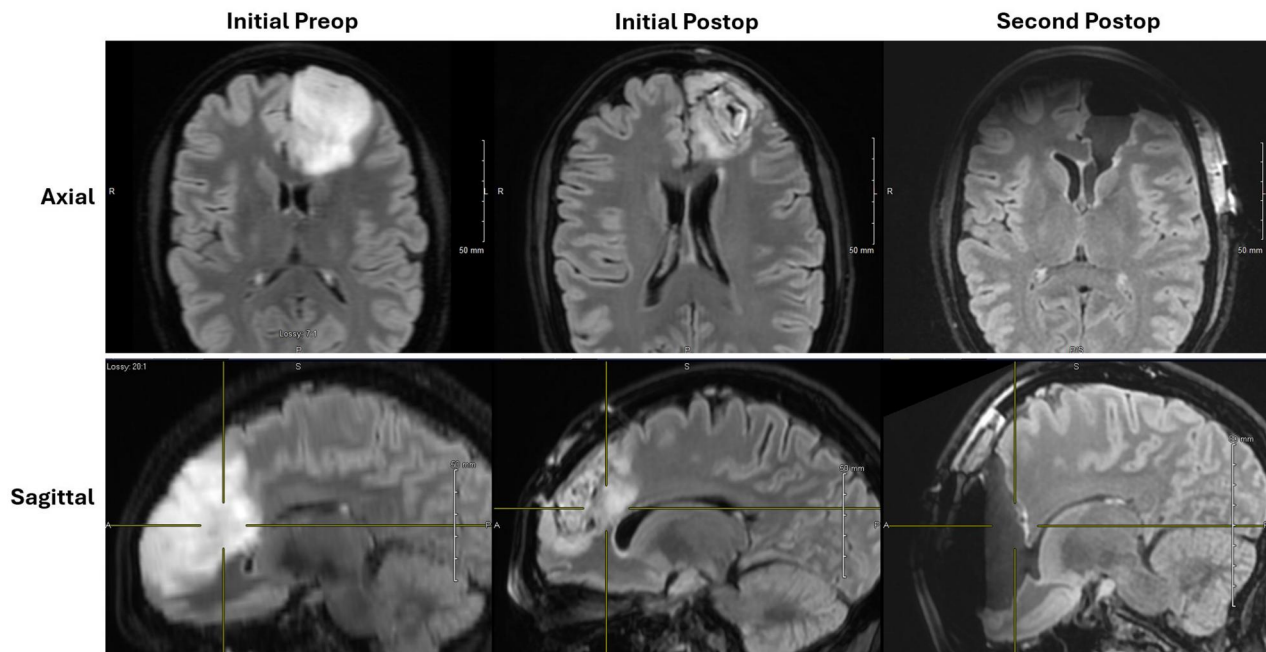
FLAIR MRIs from a 35-year-old right-handed female with a WHO grade 3 oligodendroglioma (IDH-mut, 1p/19q co-deleted) who underwent an initial craniotomy for debulking of the mass at an outside hospital and was subsequently referred for further surgical resection. According to data published by Rossi et al [25], extending her resection from subtotal (initial postop) to supramarginal (second postop) increased her median progression-free survival from 23 to >48 months.
